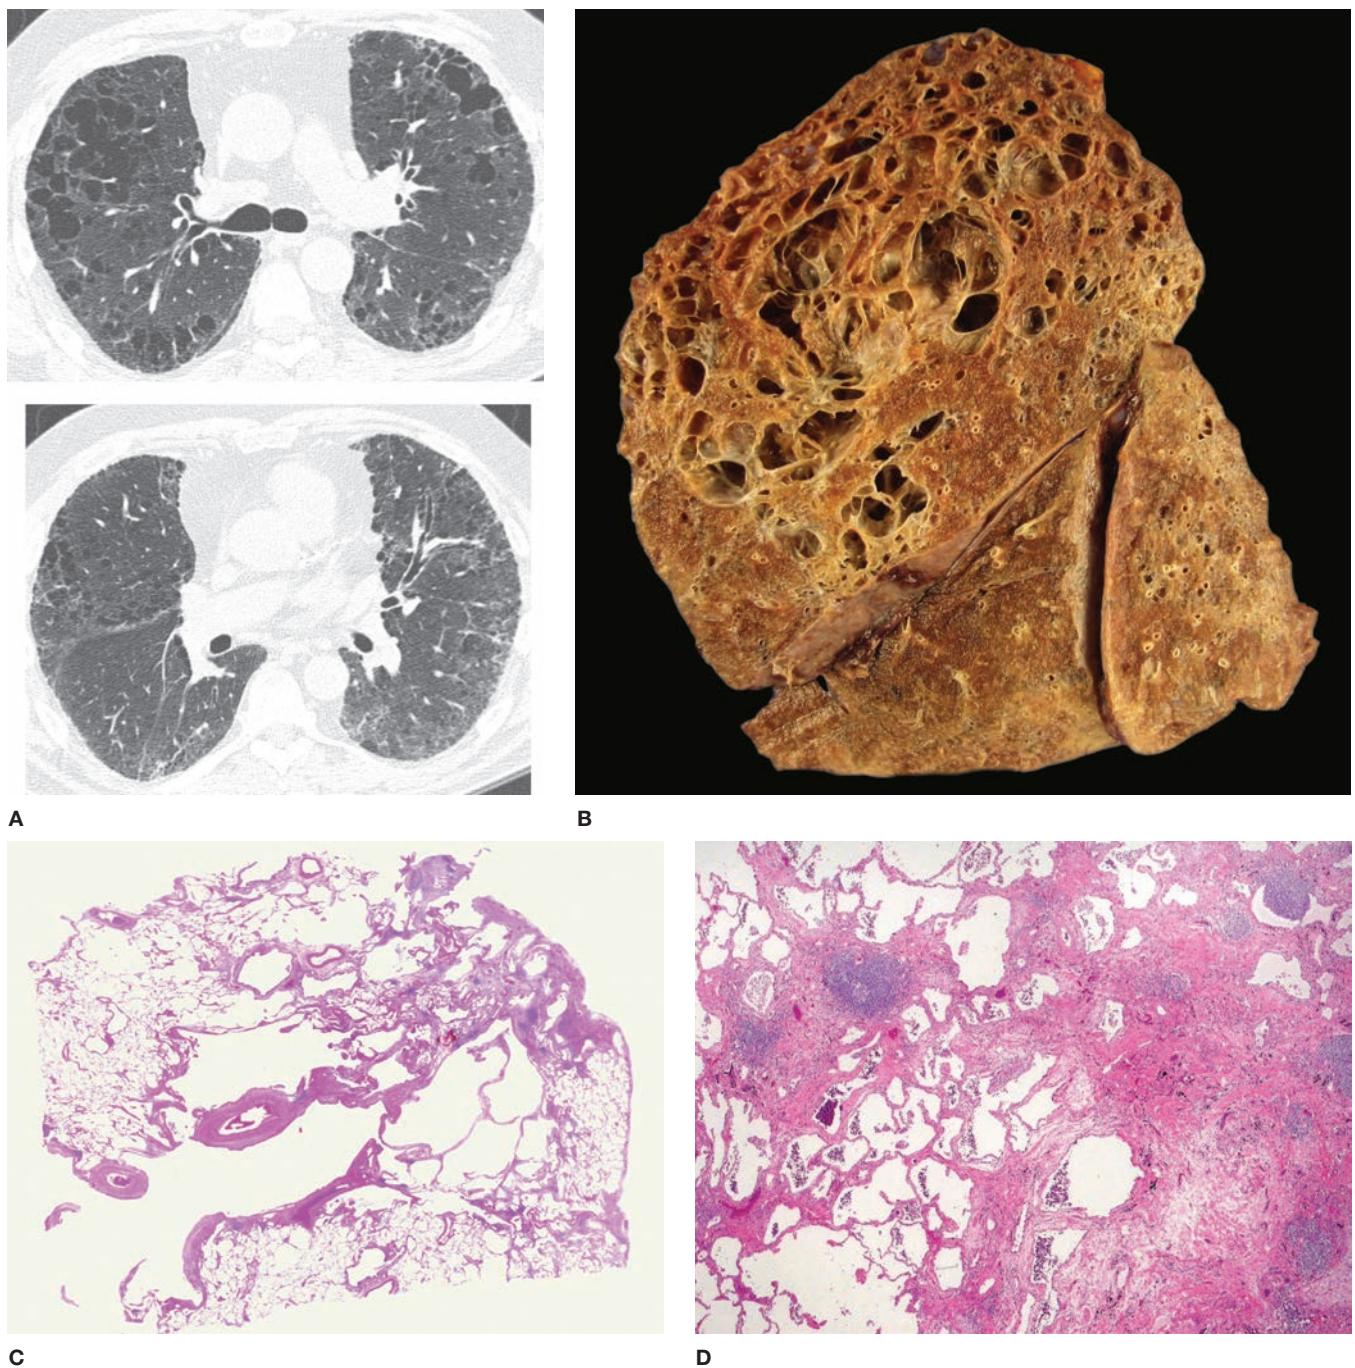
Combined fibrosis and emphysema in a case of chronic (fibrotic) hypersensitivity pneumonitis. A. Computed tomography scan from upper zone (top) shows emphysema and a suggestive of reticulation; lower image from midlung zone shows extensive reticulation indicating the presence of underlying fibrosis. B. Gross photo (sagittal slice) from this case showing marked upper zone emphysema, with fibrosis evident in the most posterior portion of the upper lobe, and the posterior portions of the lower lobe. C. Whole mount from the upper lobe. There are large emphysematous spaces, several
